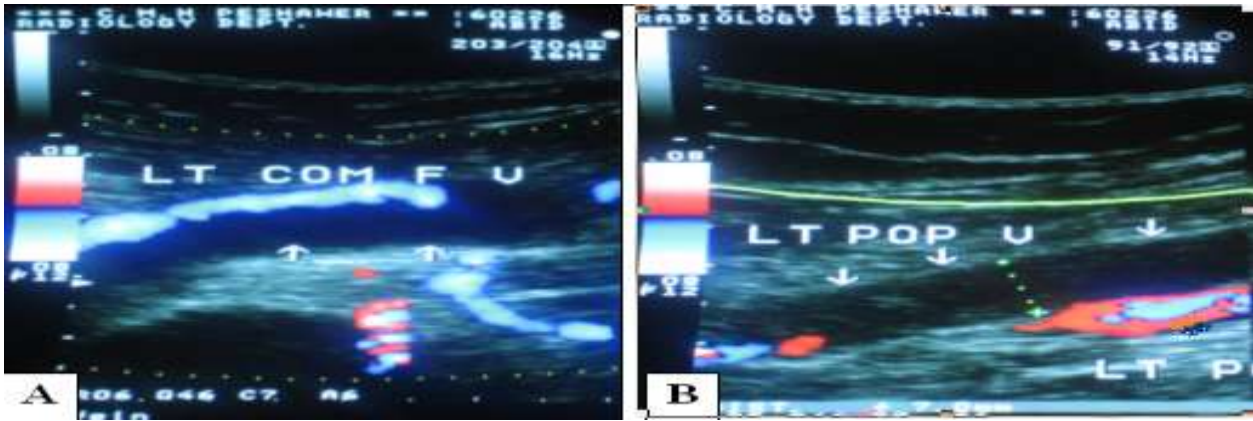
Longitudinal Color Doppler Images demonstrate hypoechoic thrombus (arrows) completely filling left common femoral and popliteal veins
